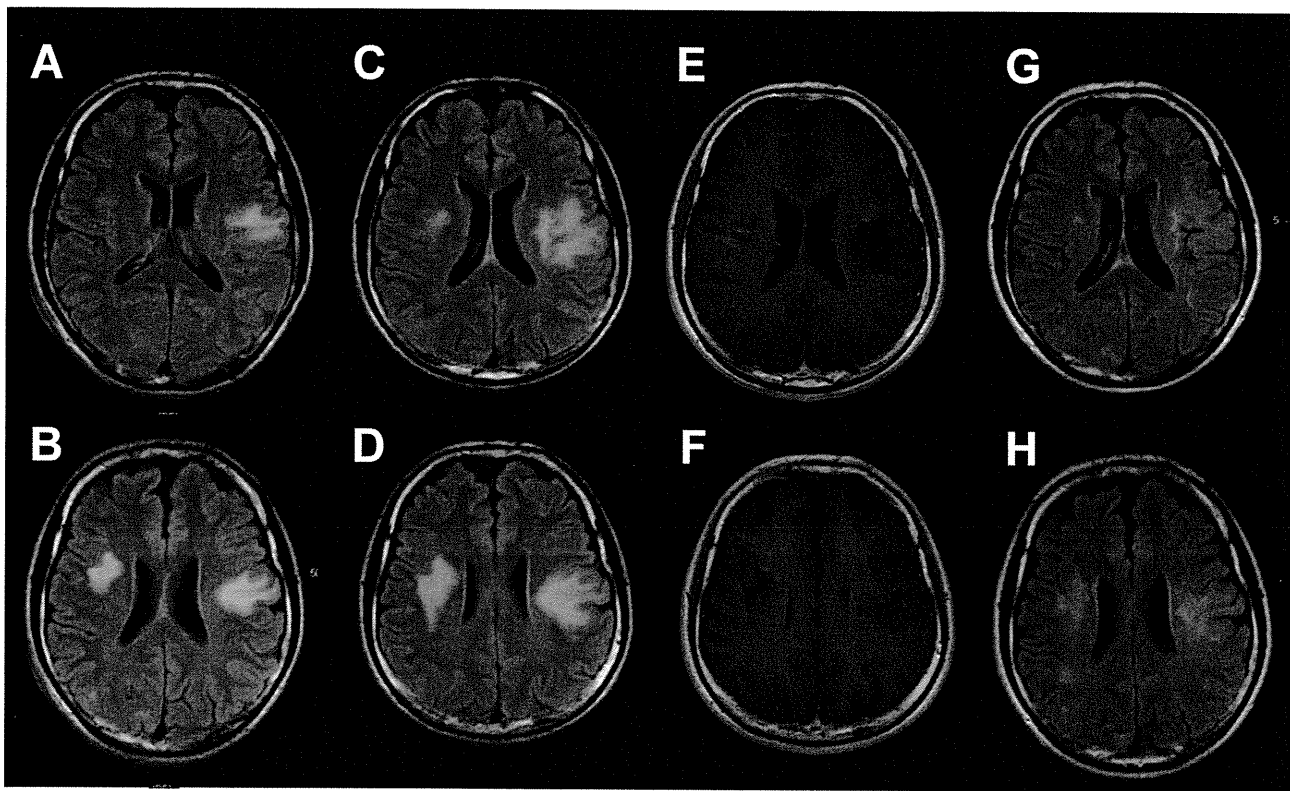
Magnetic resonance imaging (MRI) findings. (a, b) On 28 August 2009, fluid-attenuated inversion-recovery (FLAIR) imaging demonstrates areas of increased signals in the right and left bilateral occipital white matter. (c–f) Follow-up MRI on 14 September 2009. FLAIR imaging shows progression of white matter abnormalities (c, d). T1-weighted image after gadolinium injection shows mild contrast enhancement suggesting progressive multifocal leukoencephalopathy-immune re-constitution inflammatory syndrome (e, f). (g, h) FLAIR imaging shows regression of the white matter lesions in both hemispheres six months after mefloquine administration
